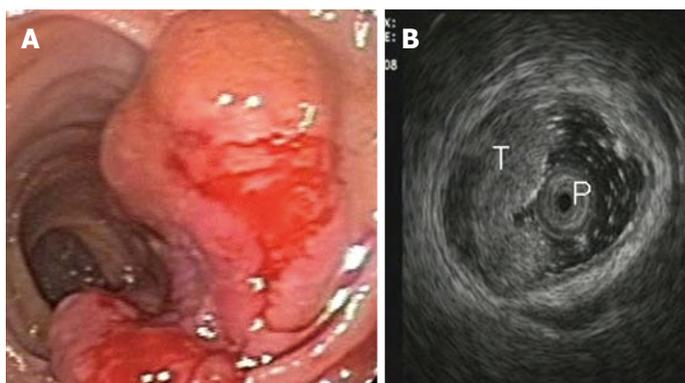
Stage T1 rectal cancer: (A) endoscopic and (B) ultrasonographic view. Endoscopic ultrasound with radial miniprobe (12 MHz), showing a small tumor located within the mucosa and superficial submucosal layers, and preservation of the outer layers of the rectal wall. T: Tumor; P: Radial probe.
